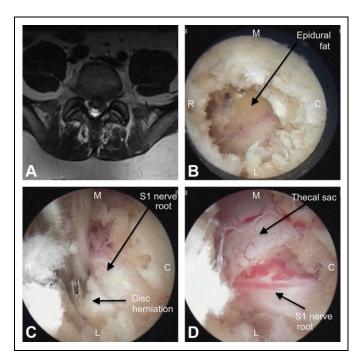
Left interlaminar L5-S1 percutaneous endoscopic discectomy. (A) Axial T2-weighted magnetic resonance image through L5-S1 depicts a left paracentral herniated disc. (B) Endoscopic view of epidural fat after opening a window through the ligamentum flavum. (C) Pituitary rongeur simultaneously retracting the traversing S1 nerve root, while removing herniated disc. (D) Postdiscectomy, the decompressed thecal sac and traversing S1 nerve root are clearly visualized. C, caudal; L, lateral; M, medial; R, rostral.
